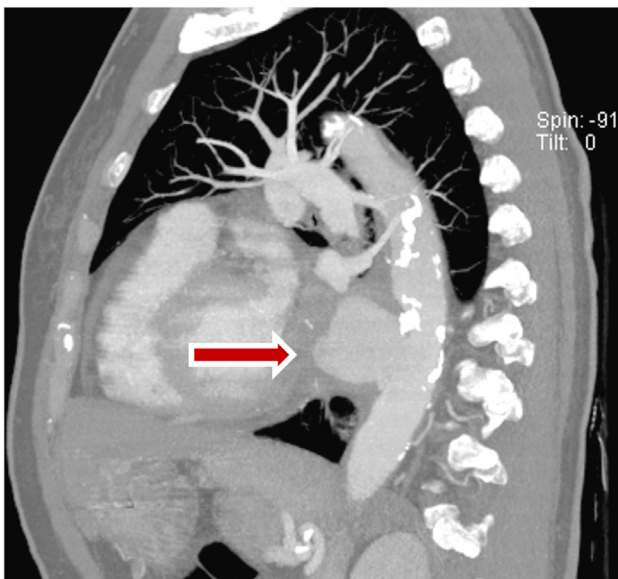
The CTA depicts a penetrating aortic ulcer (arrow) in the descending aorta without contrast extravasation
